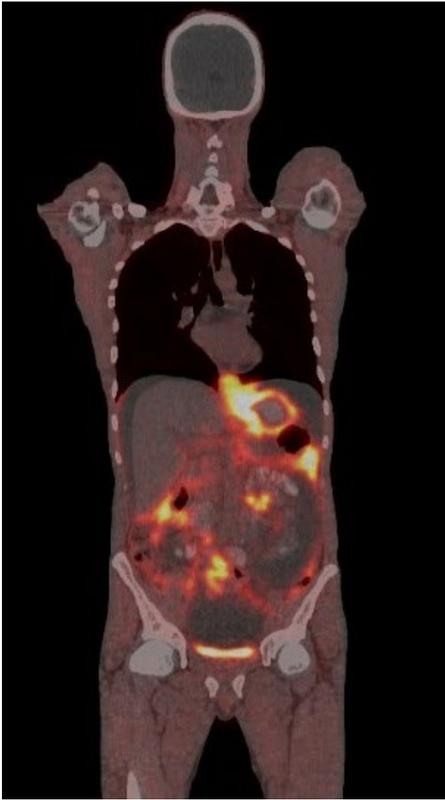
[^{68}Ga]Ga-FAPI-46 PET/CT in a patient with a gastric cancer, peritoneal carcinomatosis and ascites, T4N2M1
